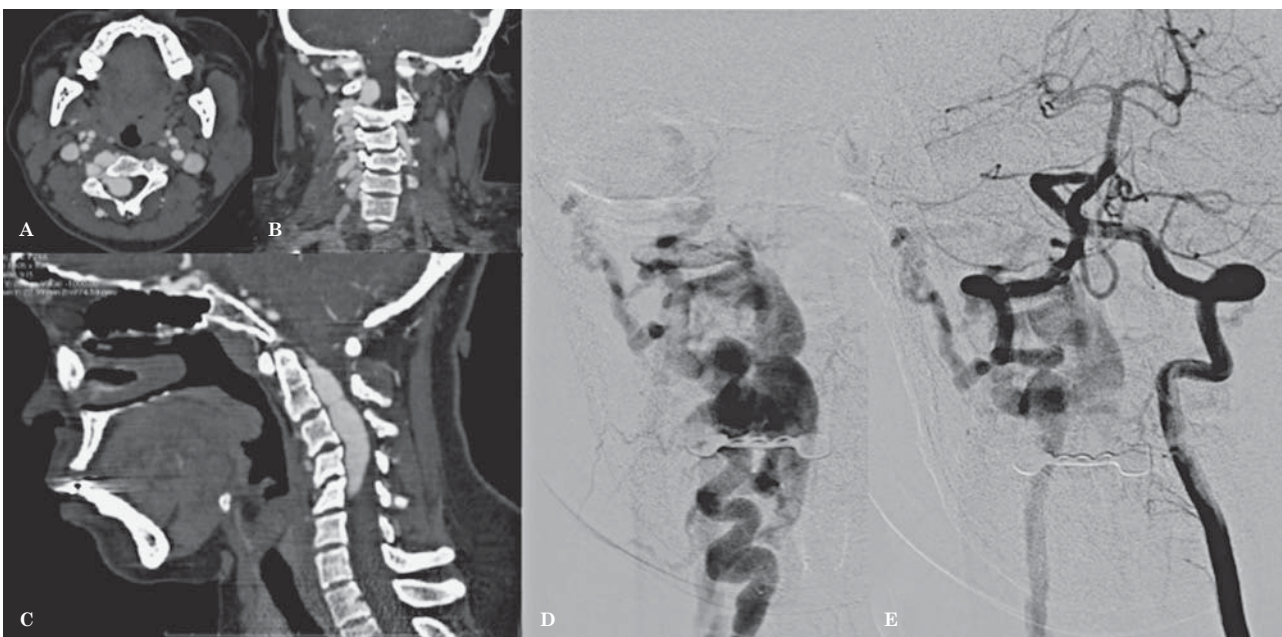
Contrast-enhanced CT angiography, MPR reconstruction (A) axial (B) coronal (C) sagittal, shows an extradural fistula of the right VA with multiple arteriovenous high-flow shunts at C2-C5 level. Pre-operative DSA right (D) and left (E) VA injection: large VVAF in NF1 with flow steal.
